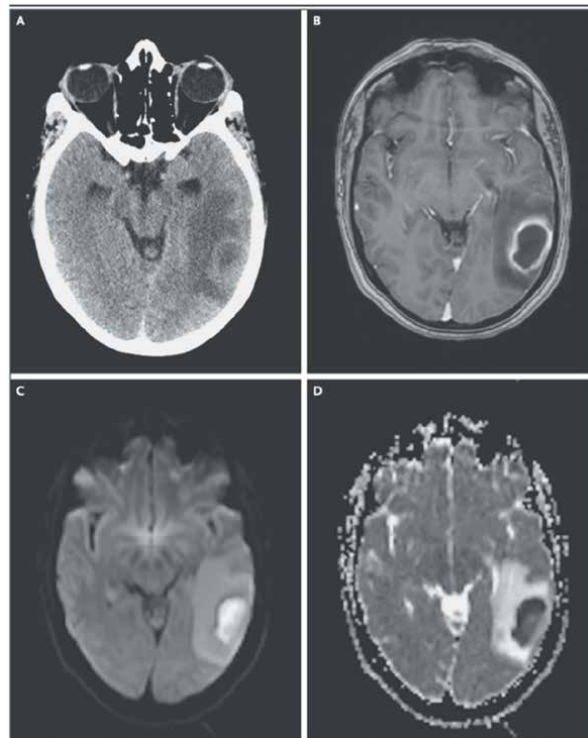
Post contrast CT imaging (A), T1- weight MRI (B), DWI (C) and apparent-diffusion-coefficient (D) imaging of intracranial abscess—Reprinted from: [1].
